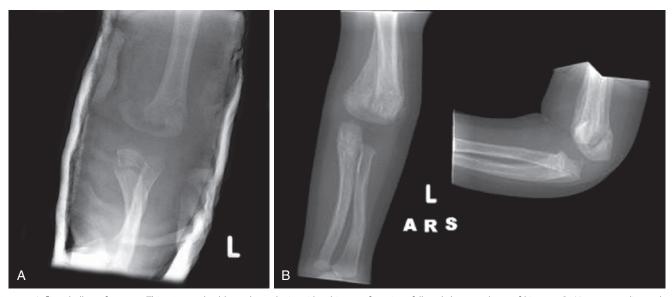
Inflicted elbow fractures. This 10-month-old was brought in with a history of a minor fall and decreased use of his arm. A, However, radiographs revealed displaced transverse fractures of both the distal humerus and proximal ulna along with marked soft tissue swelling. These findings were incompatible with the reported mechanism of injury and instead were the result of grabbing the arm and yanking the elbow into hyperextension with severe force. B, Follow-up films 1 month later show prolific subperiosteal new bone formation.
